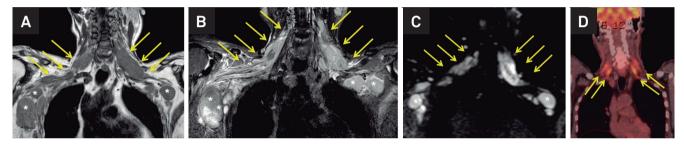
Neuroimaging of the brachial plexus. Brachial plexus MRI coronal T1 WI (A), T2/STIR WI (B) and DWI (C) demonstrating brachial plexus root infiltration with abnormal MR signal intensity (arrows). Note the fusiform aspect in most of the masses, following the larger axis of roots and trunks longitudinally. Enlarged axillar nodes are also depicted (*). PET-CT coronal images (D) reveal noticeable fluorodeoxyglucose hypermetabolism in the brachial plexus.
